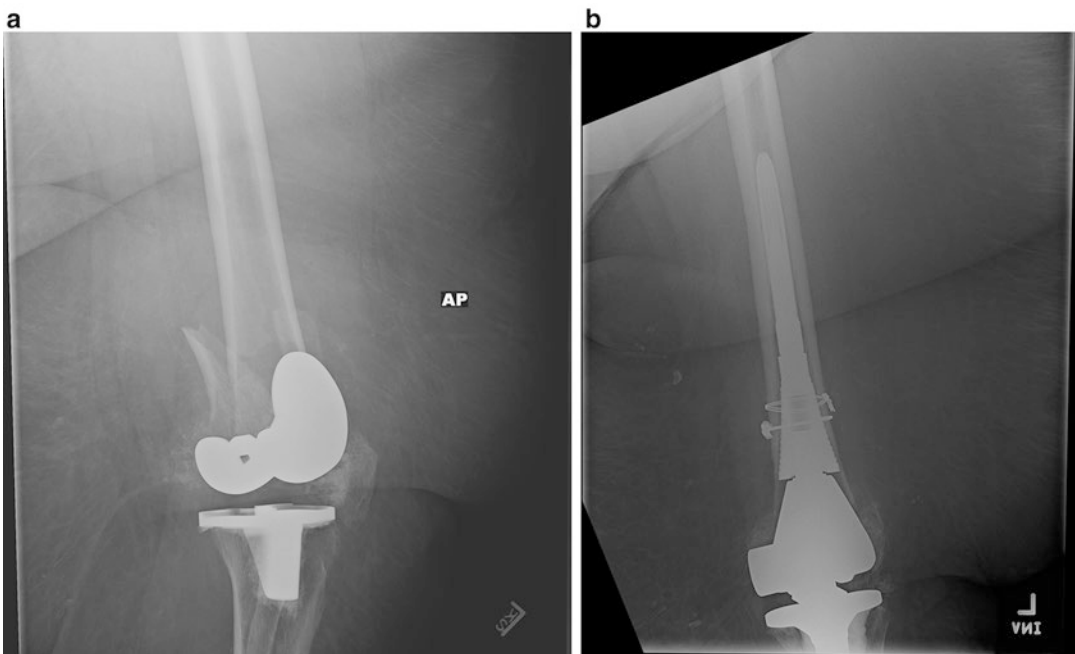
With severe comminution, bone loss, or a loose femoral prosthesis, the use of distal femoral replacement or hinged prosthesis becomes an option one must consider to allow early mobilization and early weight bearing. The AP (a) radiograph demonstrates a severely comminuted
